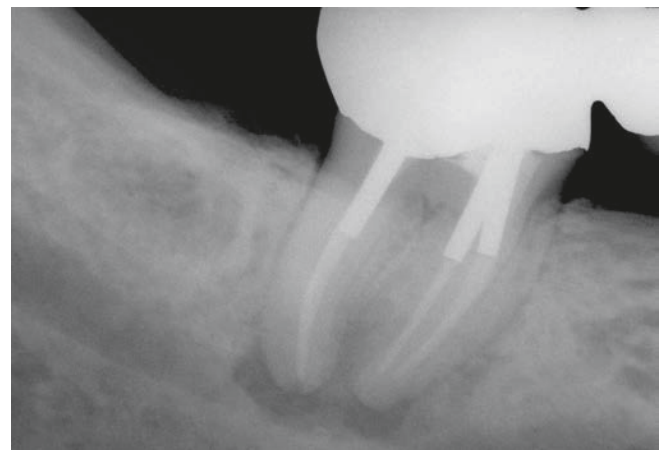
A pre-operative radiograph of this second molar bridge abutment demonstrates three posts, previous endodontics, and apical pathology.
